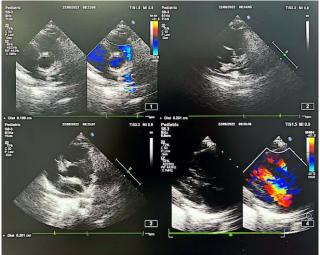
Echocardiography of the patient
